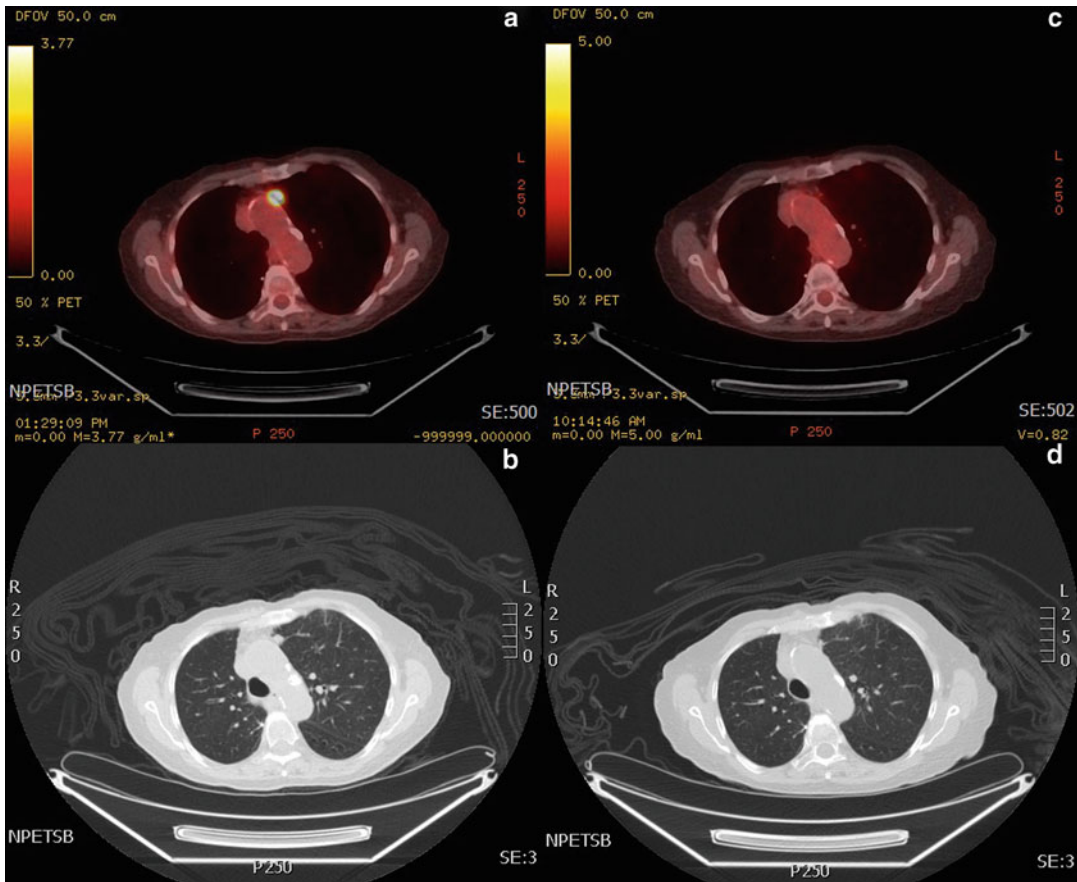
PET-CT (a) and CT (b) images of a left upper lobe cT1aN0M0 NSCLC prior to SBRT and then 3 months after treatment (c, d)
